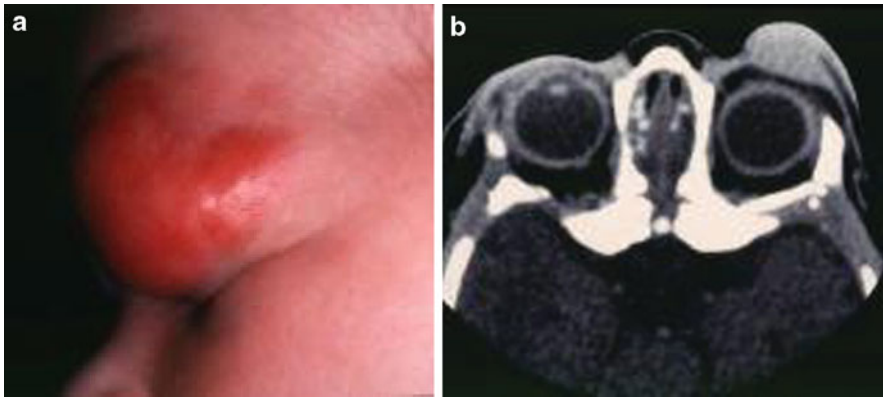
(a) Rapidly enlarging granulocytic sarcoma of the superotemporal orbit causing mechanical ptosis. (b) CT scan showing an infiltrative, homogeneous lesion in the anterior orbit and subcutaneous eyelid soft tissue. From Dutton JJ, Byrne SF, Proia AD, eds. *Diagnostic Atlas of Orbital Diseases*. Saunders; 2000. Reprinted with permission
